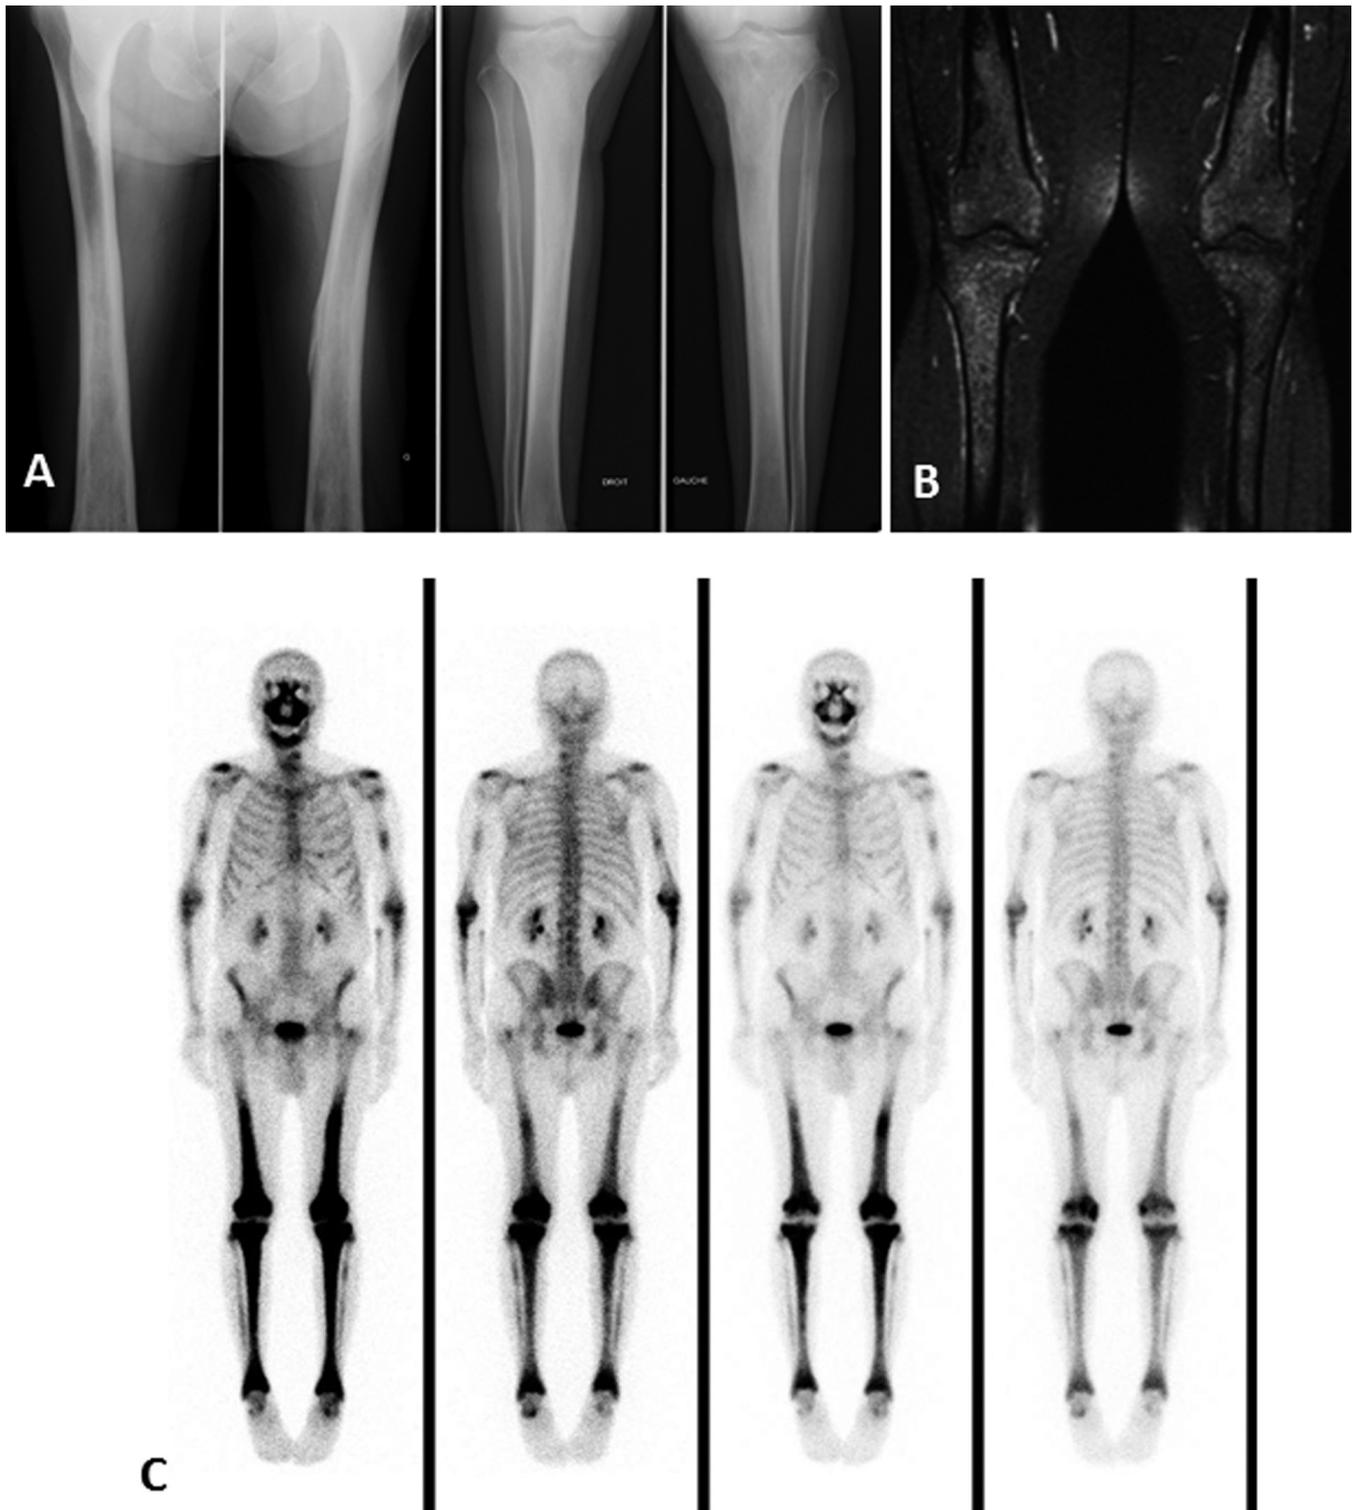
Osseous involvement in a same patient. A. X-rays: bilateral and symmetric osteosclerotic changes in diaphyseal regions of femurs and tibias. B. MRI: extensive replacement of healthy marrow fat (nonhomogeneous high signal intensity on T2-weighted sequences). C. ^{99m}Tc bone scintigraphy: symmetric increased uptake in femoral and tibial diaphyses, as well as intense uptake in the maxillary bones and moderate uptake in the humerus.
